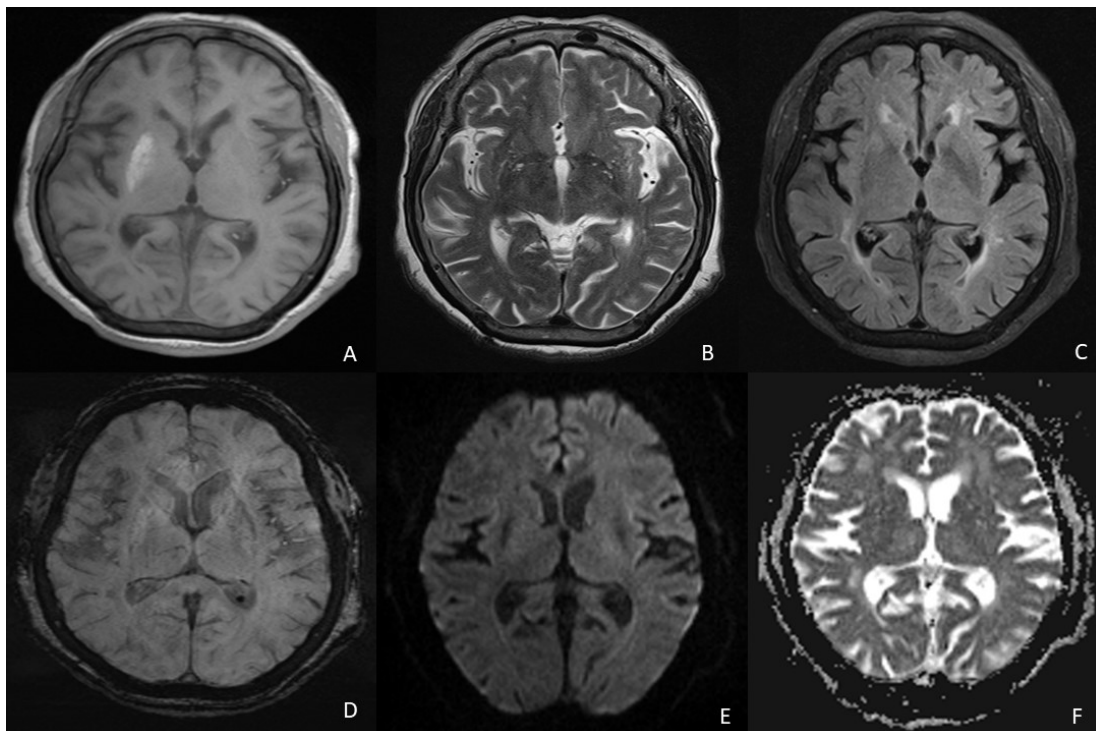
MRI brain of the patient (T1 weighted image-A) shows right putaminal hyperintensity. T2 weighted sequence(B), FLAIR (C) shows periventricular hyperintensity. Susceptibility weighted imaging (D), diffusion weighted imaging (E), and ADC(F) are normal
